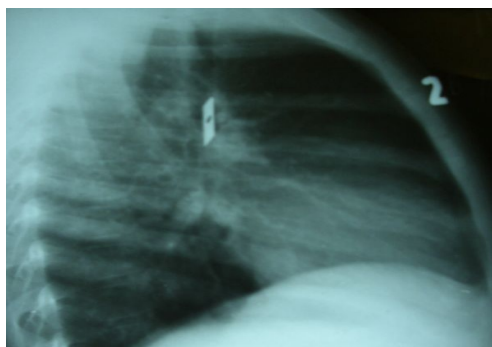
metallic FB. in lateral Chest X-ray.
